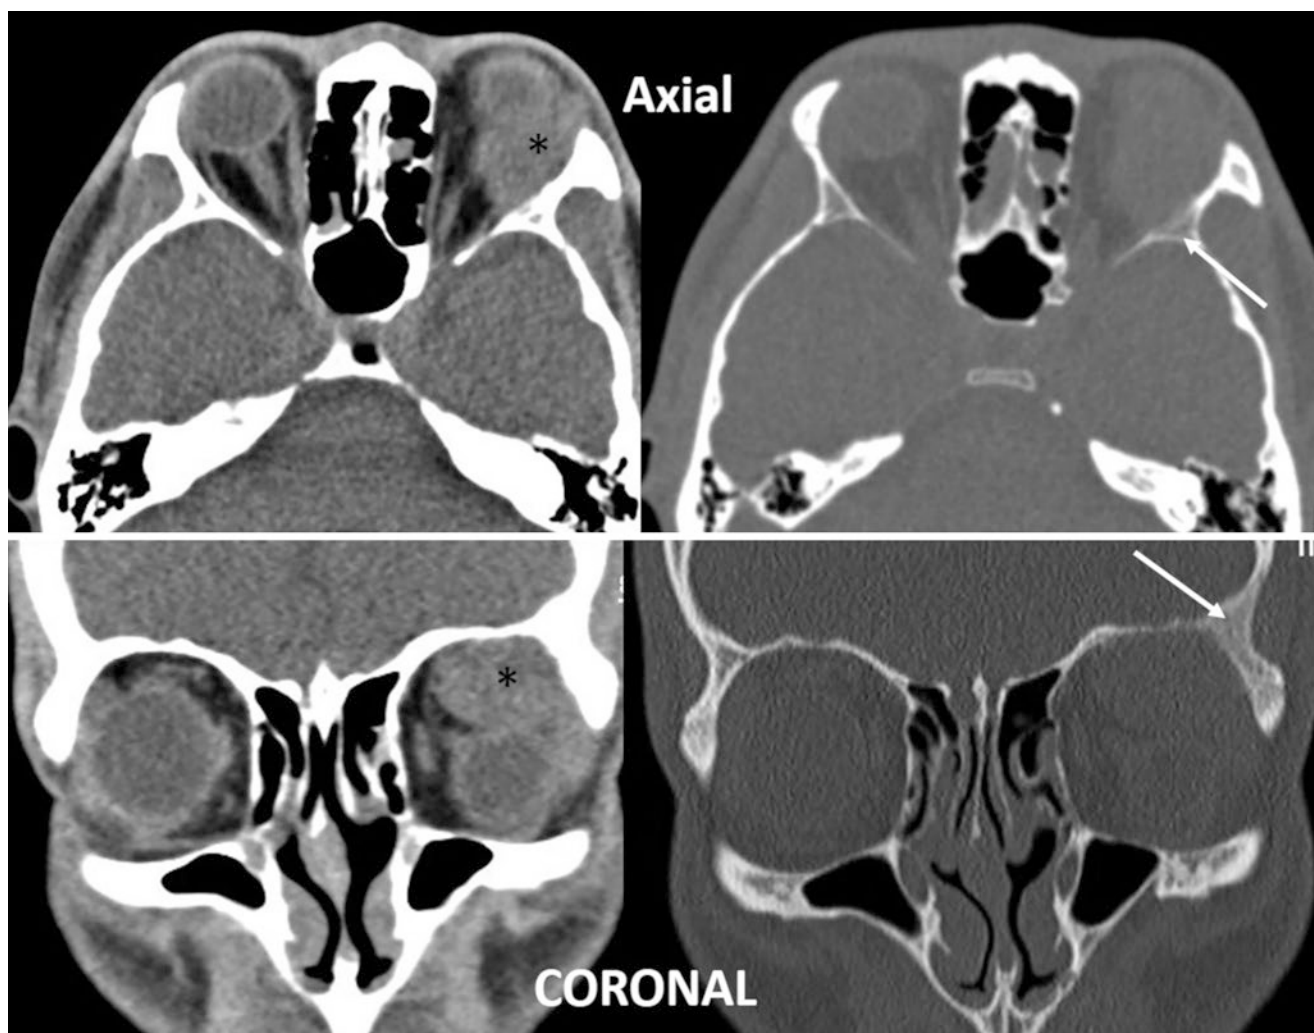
CT scan of the orbits (soft-tissue images -left and bone window images- right) showing a left extraconal mass (*) with erosion of the adjacent bone (white arrows)
